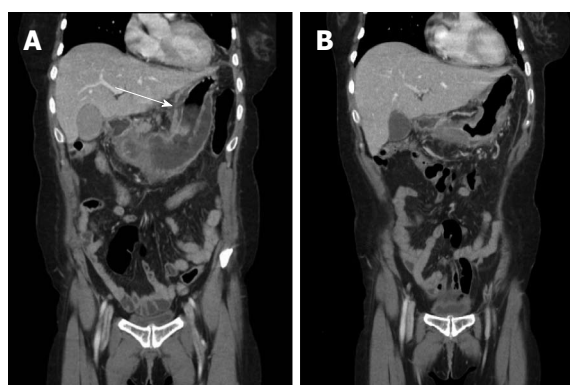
Computed tomography reconstructed images. A: The computed tomography (CT) showed a focal mucosal defect at the lesser curvature side of the body (white arrow), POD 9; B: CT revealed improvement in the state of thickening and fluid collection at the submucosal layer of the gastric body and antrum, POD 29. POD: Postoperative day.
